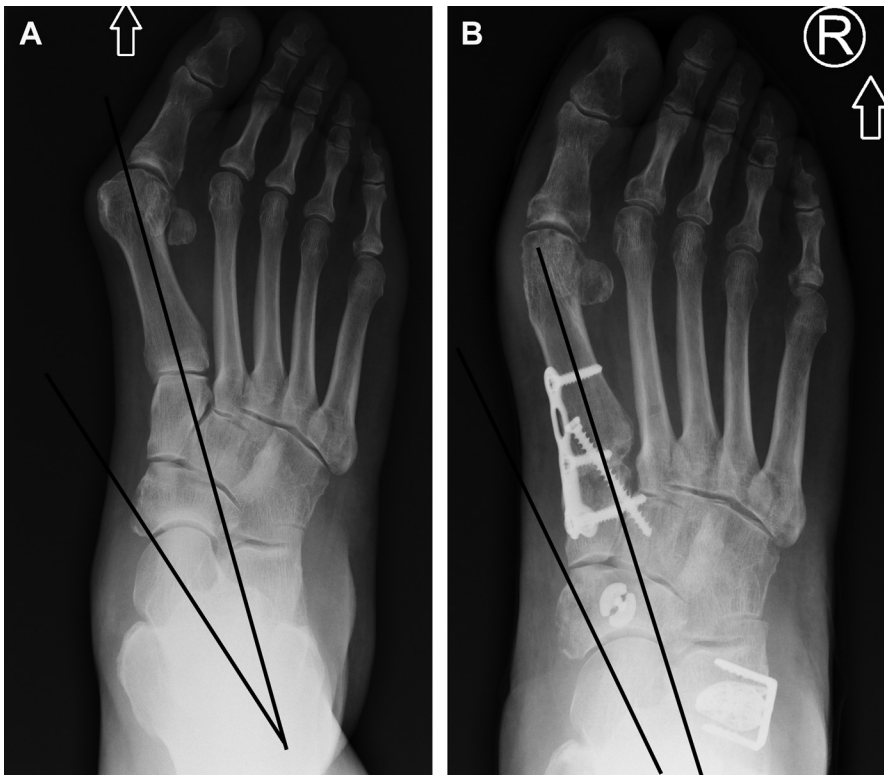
Preoperative AP radiograph (A) with 50% abduction of the TN joint with associated hallux valgus deformity. Improvement in the coronal plane deformity was noted at 1 year postoperative (B) following an MDCO, LCL, gastrocnemius recession, spring ligament reconstruction, and Lapidus. Critically, insufficient correction of the hallux deformity is noted, with approximately 20% abduction of the TN joint. The patient is clinically satisfied despite failure to completely correct the abduction.
